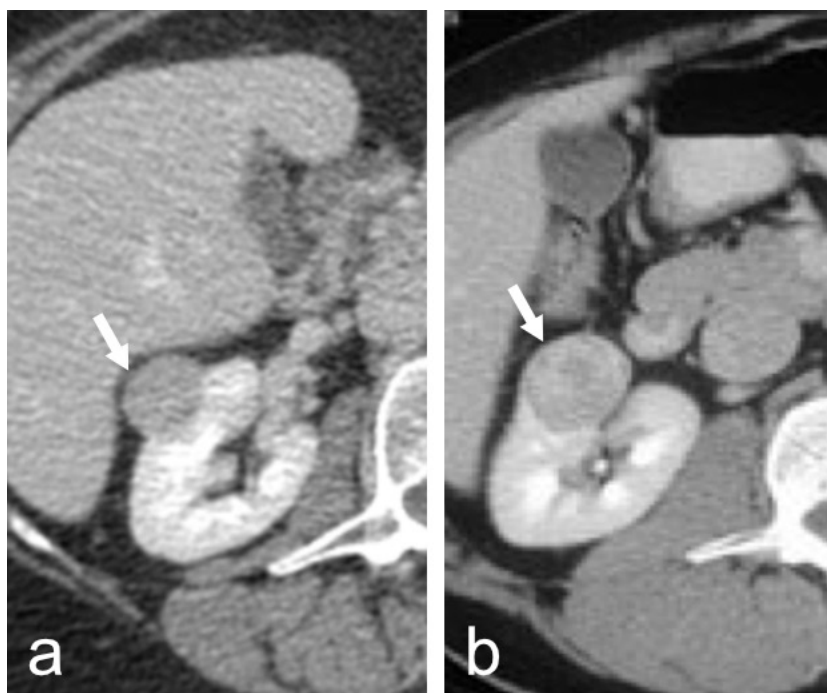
Two different patients, two different renal tumours (arrows) incidentally discovered. Contrast-enhanced axial CT scans of the abdomen exhibiting small tumours on the right kidney. Both tumours share common imaging characteristics which makes an accurate preoperative diagnosis difficult. The tumour on the left (a) turned out to be RCC of clear cell subtype while the tumour on the right (b) was postoperatively diagnosed as a benign RO. (Karolinska University Hospital Huddinge, MIDOR study)
